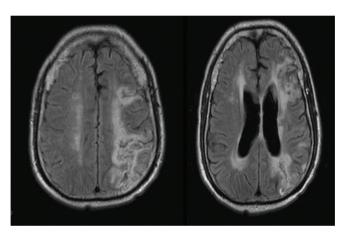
MRI Brain T2 FLAIR sequence shows left frontoparietal and occipital abnormal signal alteration involving cortical and subcortical area. Consistent with left MCA infarction
